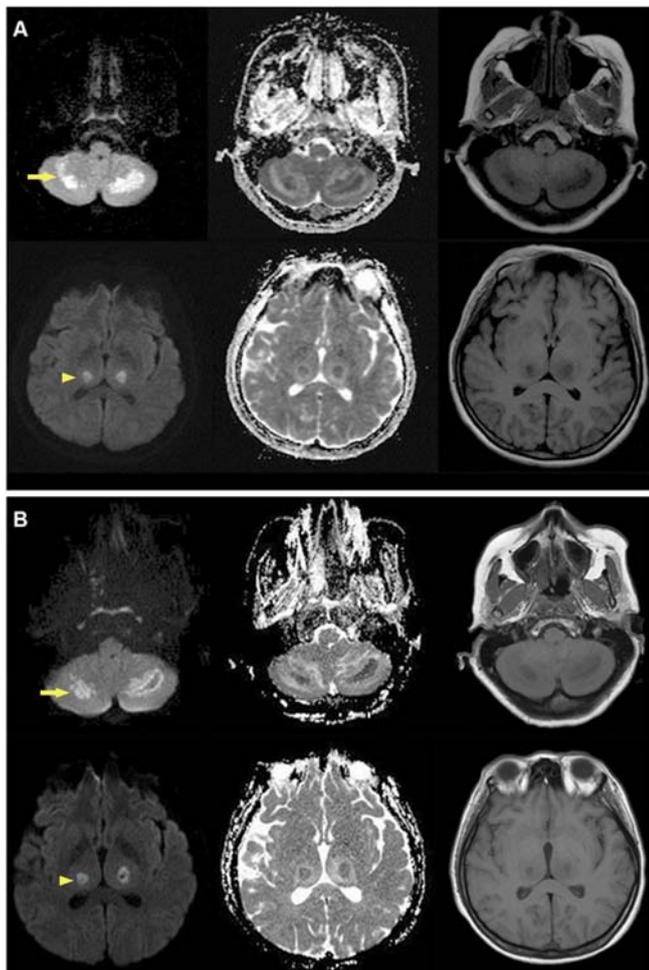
(A) Brain MRI (axial view) revealed symmetrical bilateral hyperintense lesions in the cerebellum (arrows) and the thalami (arrowheads) on diffusion-weighted imaging (left), associated hypointense on the apparent diffusion coefficient-map (center), and T1 weighted imaging (right) in the corresponding areas at initial diagnosis of influenza-associated acute encephalopathy. (B) Central necrosis of these lesions was seen in the brain MRI series 48 h after onset.
